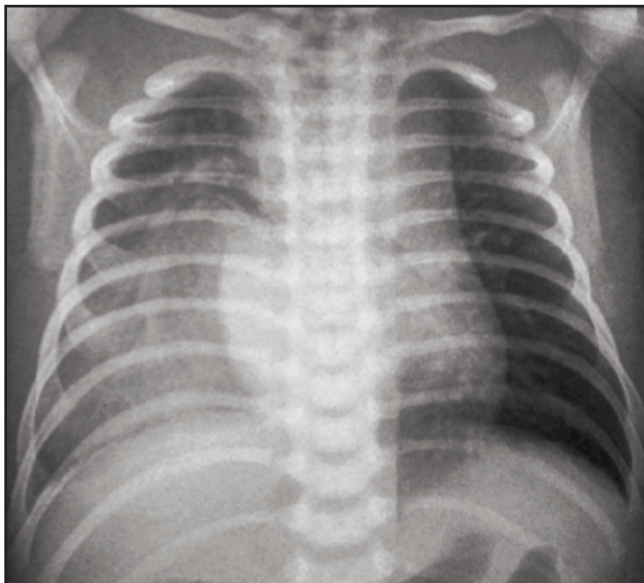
Chest radiograph showed an area of homogenous opacity in the mid and lower zone of the right lung with intact right heart border and right hemidiaphragm.
